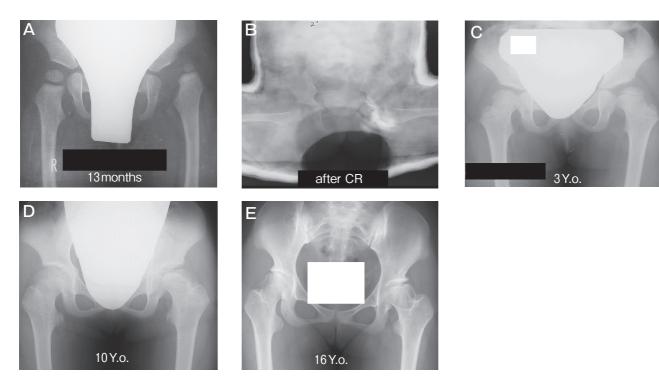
Sample case with prior CCR. A, Left-side developmental dysplasia of the hip at 13 months of age; B, Lorenz closed cast reduction was performed; C, X-ray imaging at the age of 3 years; D, X-ray imaging at the age of 6 years; E, X-ray imaging at the age of 16 years.
